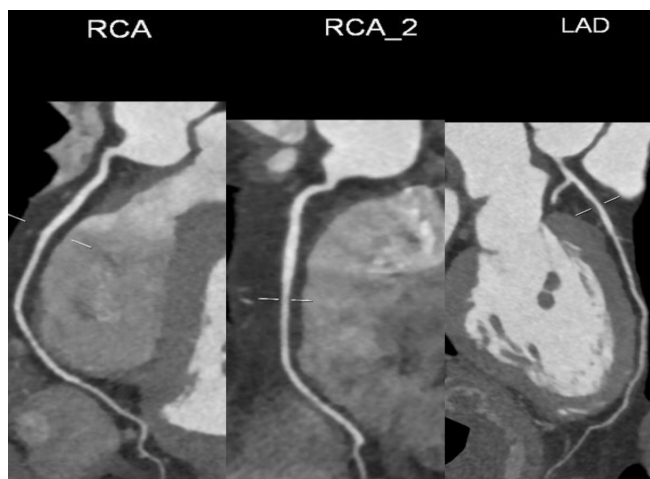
Coronary Computer tomography (CT) Angiography images of the patient. The patient's CT coronary showed no lesions in the coronary arteries
